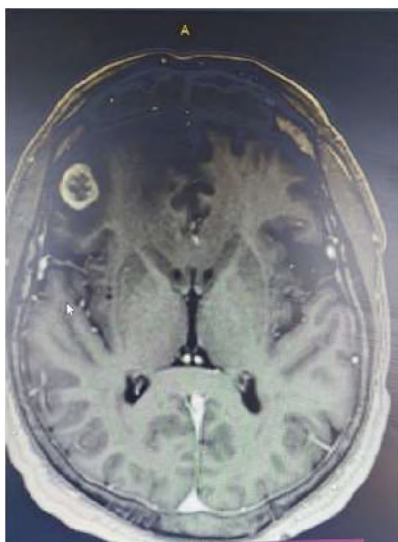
CT, Patient 1, after surgery
